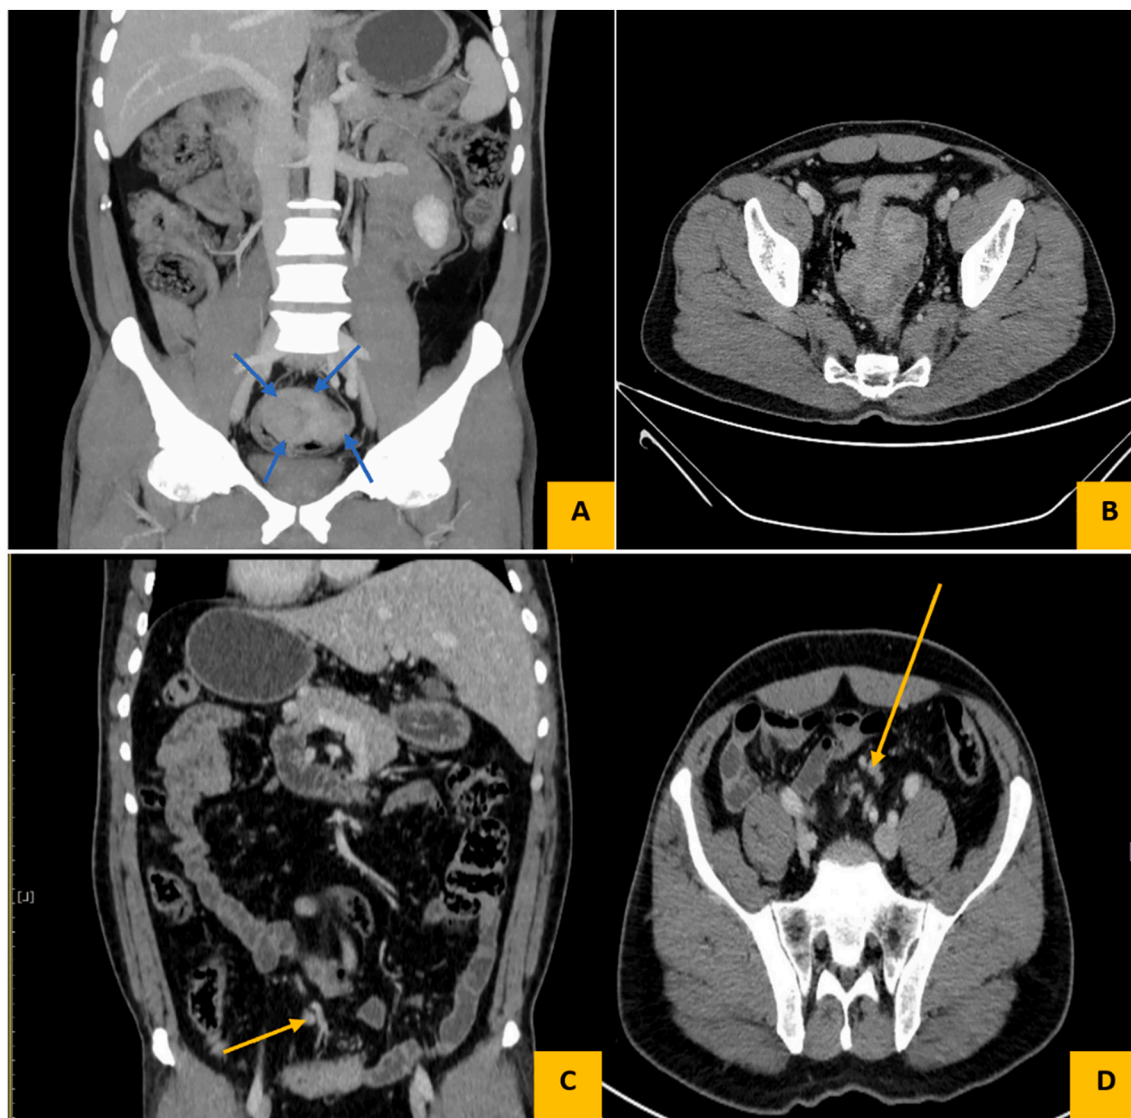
The abdominal CT showed diffuse wall thickening of the sigmoid colon and distal part of the left colon (blue arrows in A), associated with enhancing soft tissue mass measuring about 72 mm × 40 mm in sigmoid colon that was suggestive of a malignant process. Evidence of multiple regional lymph nodes was seen adjacent to the sigmoid colon (yellow arrows).
